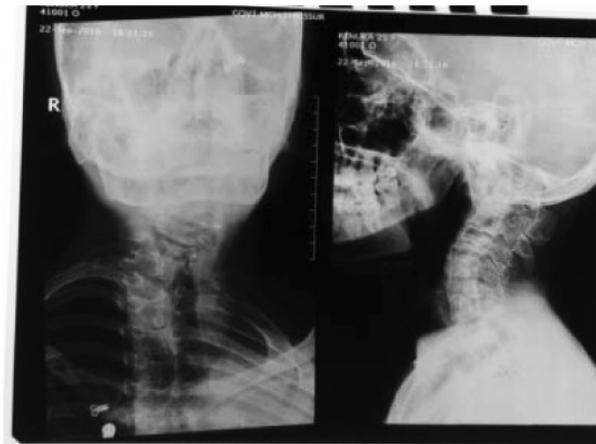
X-ray cervical spine Fused cervical vertebrae
